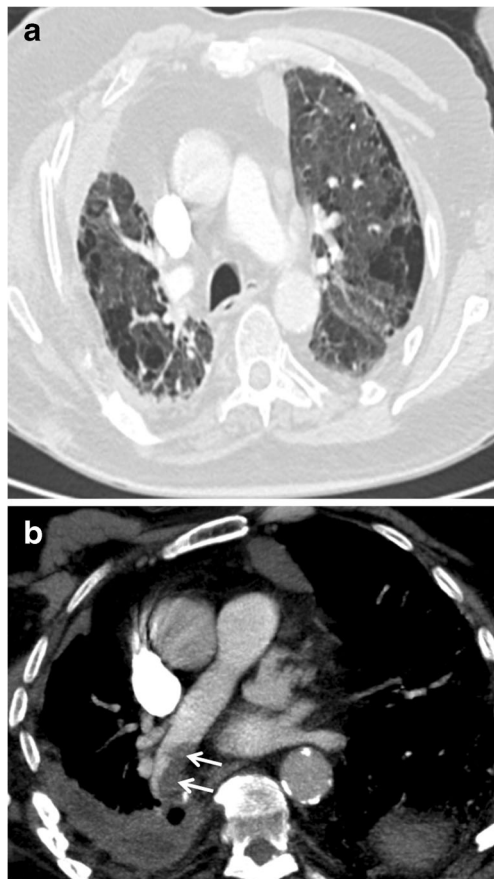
Pulmonary embolism in a 78-year-old man with unexplained exacerbation of chronic obstructive pulmonary disease (COPD). a Axial computed tomography pulmonary angiography (CTPA) image (lung window) shows diffuse emphysematous changes in both lungs. b Axial maximum intensity projection (MIP) CT image showing a filling defect (arrows) in the right lower lobe pulmonary artery consistent with pulmonary embolism
